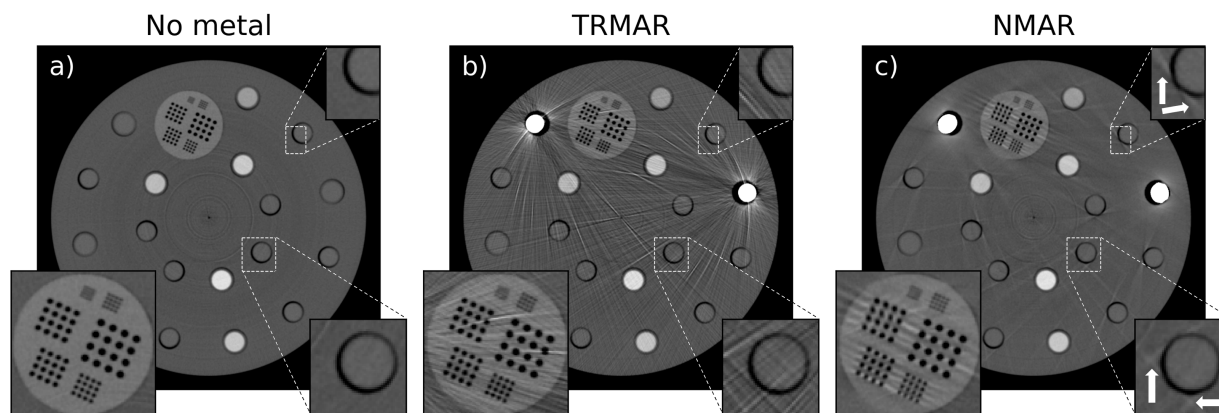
CT reconstructions a) without metal b) with the 100–110 keV TRMAR in the 30–120 keV energy bin and c) NMAR in the 30–120 keV energy bin. Inserts show areas with introduced artifacts in NMAR (white arrows). $W/L = [1300/150 \text{ HU}]$.
